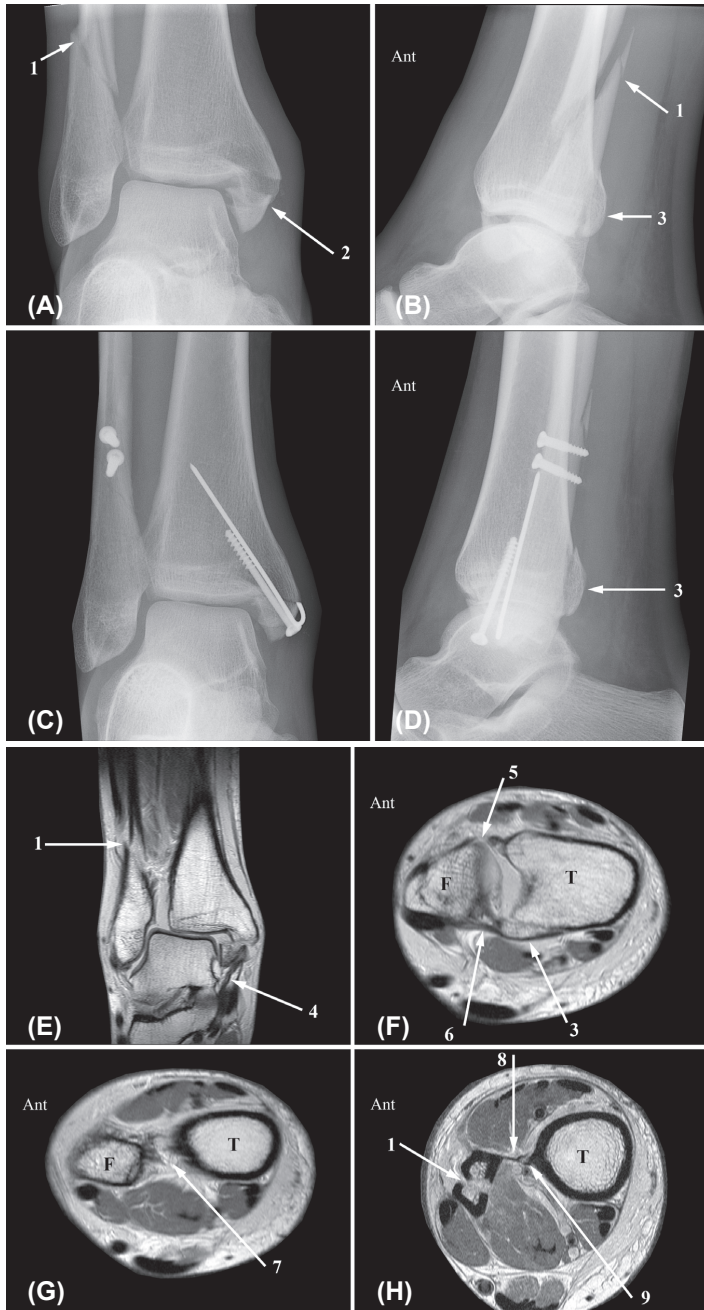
AP (A) and lateral (B) radiograph show an oblique fibula fracture (1), running from antero-inferior to postero-superior, characteristic of a supination-external rotation injury. The medial malleolus (2) and posterior malleolus (3) are avulsed. AP (C) and lateral (D) radiograph after open reduction and internal fixation without a setscrew. The fracture of the posterior malleolus (3) is visible and not fixed. The fracture was classified as: Weber type C, AO-Müller C2.3, Lauge-Hansen SE4. Coronal (E), 45° oblique (F; G), and axial proton-density-weighted (H) MR image. The coronal MRI shows the laterally dislocated talus, with a distal fibula fracture (1) and an avulsion fracture of the medial malleolus (2) attached to a thickened but intact superficial deltoid ligament (4). In (F) the ATIFL (5) is ruptured, whereas the PTIFL (6) is intact and attached to an avulsion fracture of the posterolateral malleolus (3). In (G) the ruptured interosseous ligament (7) is visible. In (H) the fibula fracture (1) runs proximal to the interosseous membrane (8) which has a small tibial avulsion (9) up to this level. Ant, anterior; T, tibia; F, fibula.
